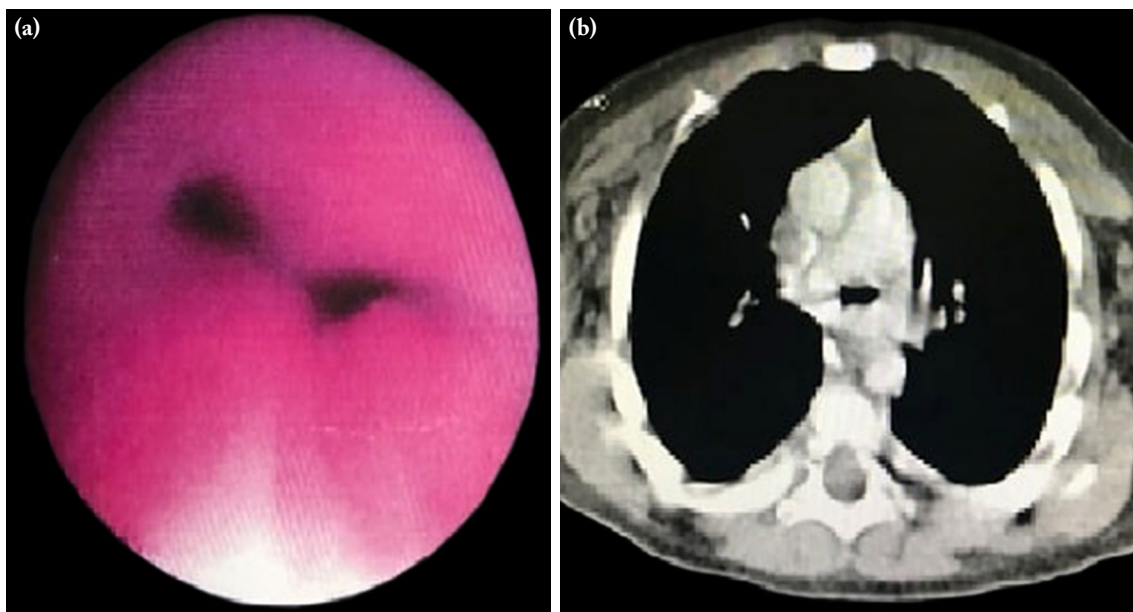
(a) Bronchoscopy image showing compression on the posterior lateral wall of the right main bronchus. (b) Computed tomography image showing pulmonary artery sling.
